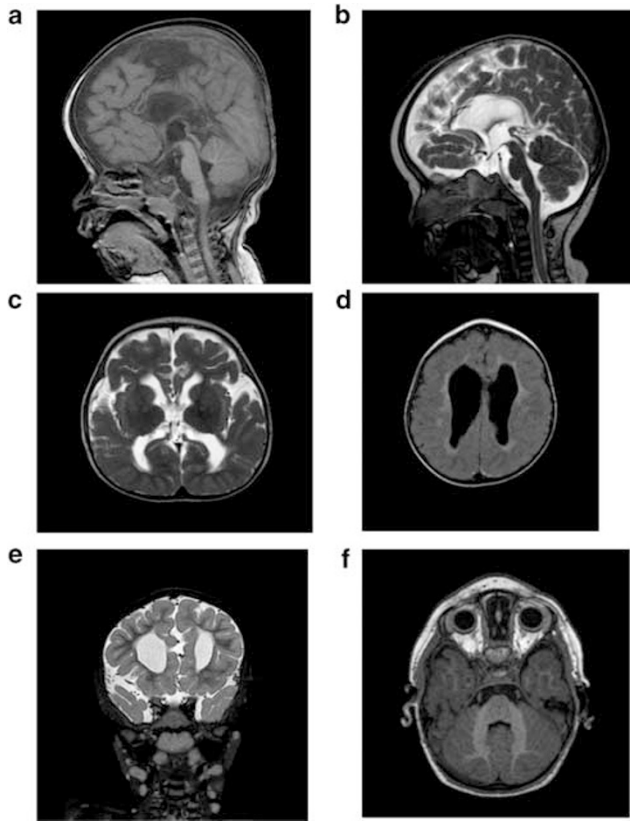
(a–f) MRI images of two affected individuals, V7 (a, T1 sagittal; c, T2 axial; e, T2IR coronal) and IV5 (b, T2 sagittal; d, T2flair axial; f, T1 axial), at 1.5 and 2 years, respectively. Note the very thin corpus callosum, generalized brain atrophy and enlarged ventricles.
